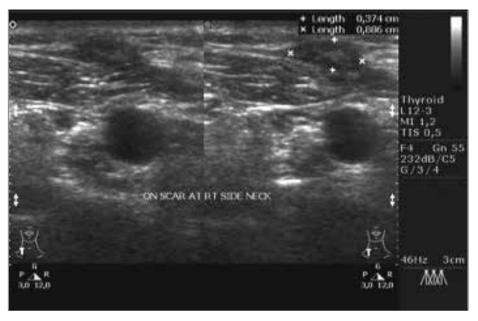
Ultrasound of the neck showing a well-defined heterogeneous lesion in the subcutaneous tissue measuring 0.4×0.9 cm (arrow)
